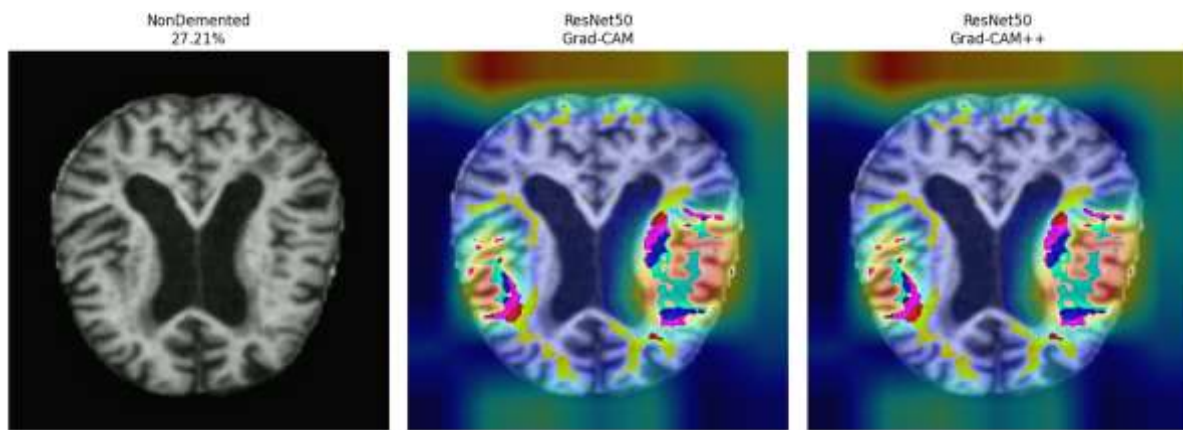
Grad-CAM and Grad-CAM++ visualization for an MRI slice classified as Non-Demented (27.21% confidence) using ResNet50.
